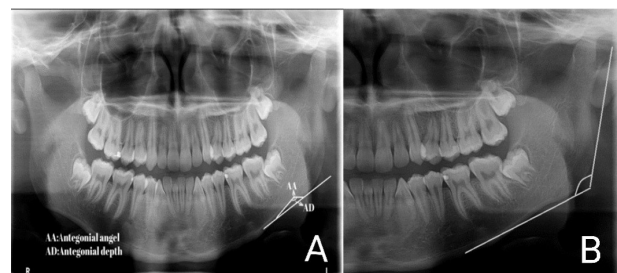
Measurements on the panoramic radiography. A: antegonial depth and antegonial angle, B: gonial angle.
